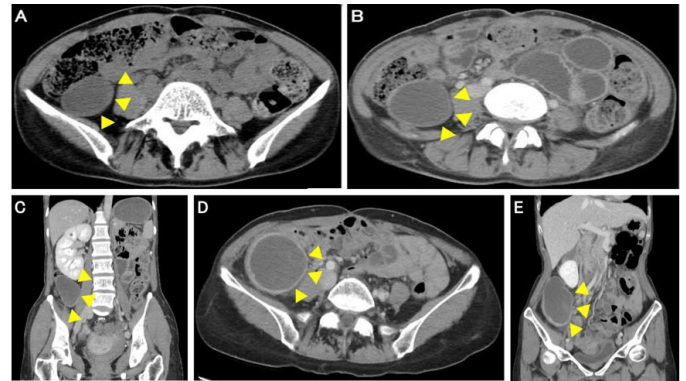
Abdominal CT images. Arrowhead: Tumor. (A) Abdominal CT from 2010 showing a cystic lesion, 4 cm in diameter, in the right lower abdomen. (B, C) Abdominal CT from 2016. The cyst had increased in size to 5 cm and was continuous with the appendix. (D, E) Abdominal CT on admission revealed a cyst approximately 9 cm in diameter with elevated surrounding fatty tissue density.
